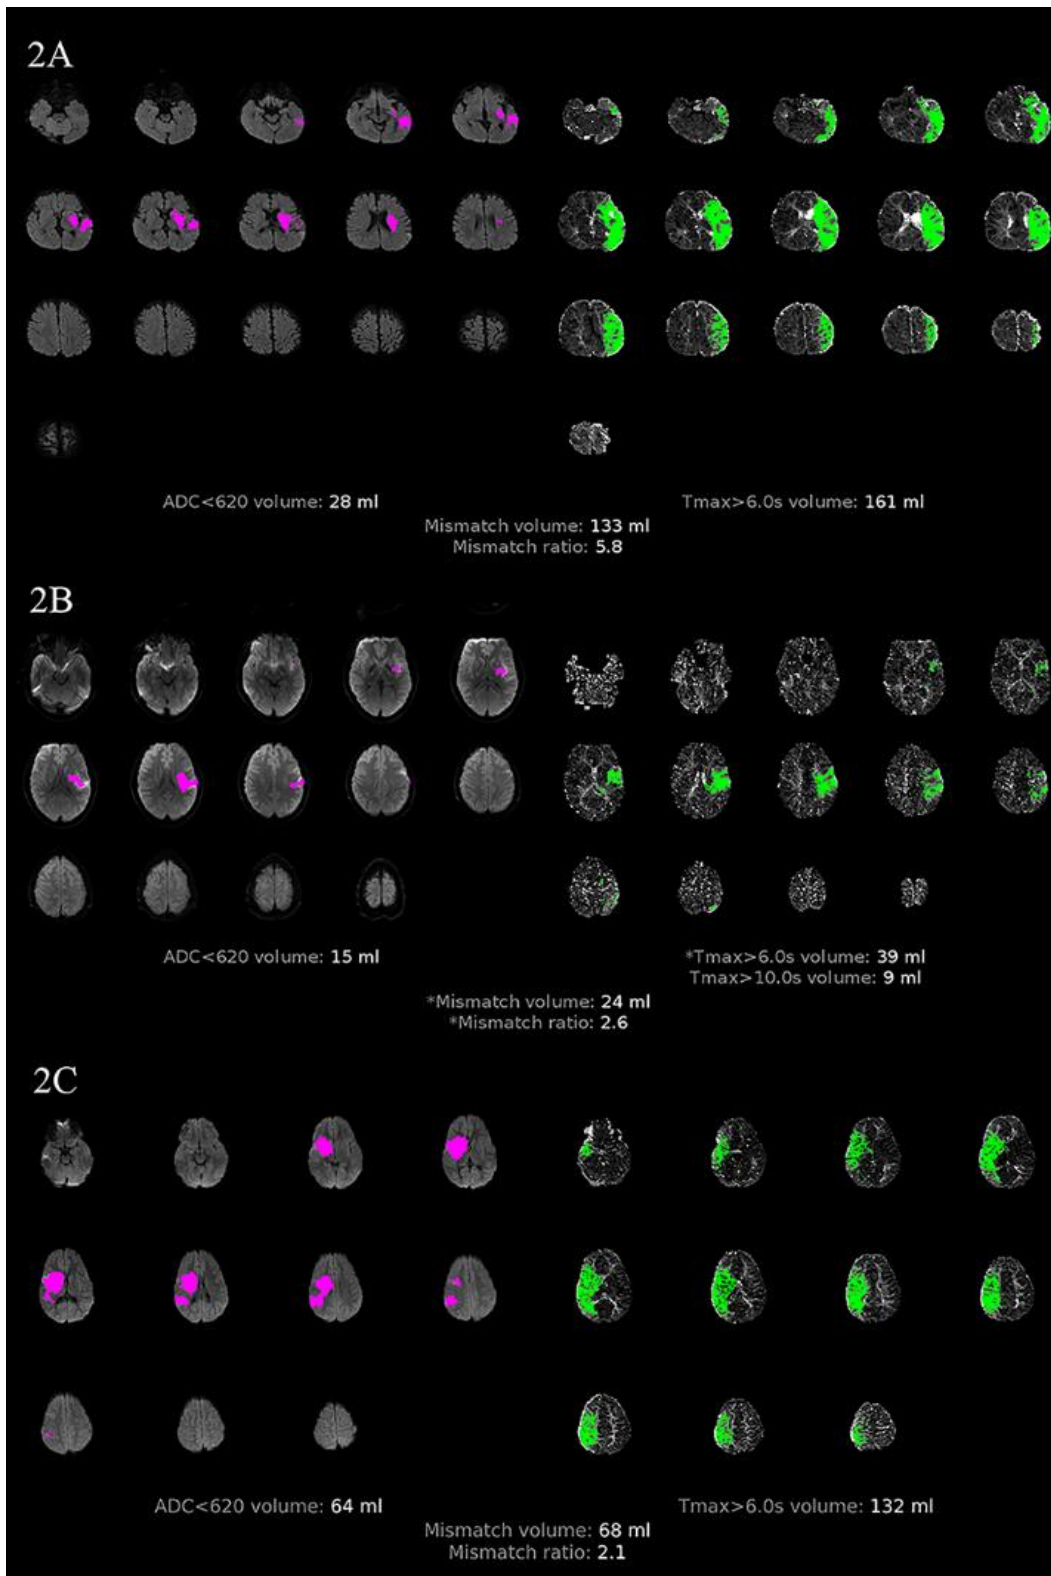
RAPID imaging for children with favorable mismatch profiles. Figure 2A is a 22-month child with a cardioembolic left MCA stroke, in the setting of hypoplastic left heart syndrome. MRA showed a left M1 occlusion. Diffusion (left) and  $T_{max}$  perfusion (right) MRI at 3.75 hours post-onset. Figure 2B is a 15-year-old child with a cryptogenic left MCA territory stroke. MRA and echocardiography were normal. Diffusion (left) and  $T_{max}$  perfusion (right) MRI at 11 hours post. Figure 2C is a three-year-old child with a focal cerebral arteriopathy resulting in a left MCA territory stroke. Diffusion (left) and  $T_{max}$  perfusion (right) MRI at 23.5 hours post-onset. Note: varying slice numbers due to different slice thicknesses for output view.
